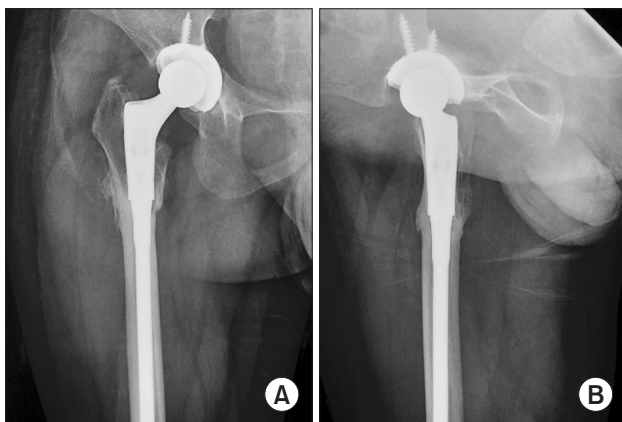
Final Follow-up radiographs of patient 1. (A) Anteroposterior. (B) Lateral.
